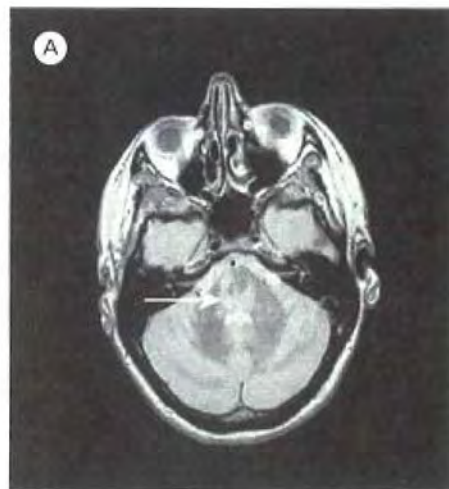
Multiple sclerosis. T₂-weighted MRI scans. (A) Lesion in the brainstem. (B) Lesion in the cerebellar white matter.
